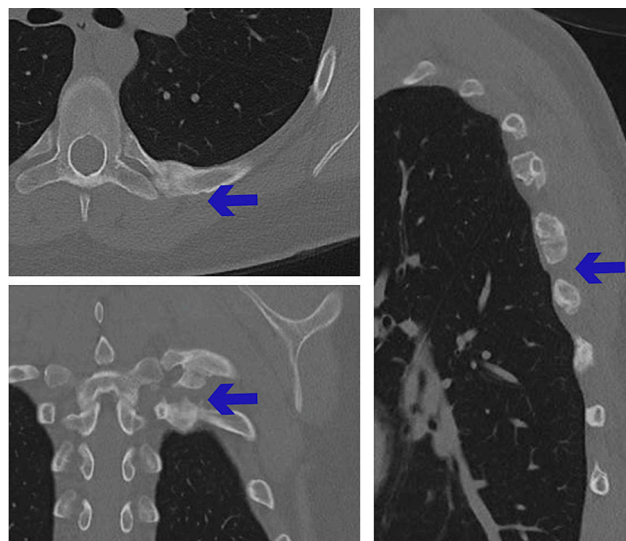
Seven months post-operative chest CT-scan demonstrating remodeled ribs 4 to 8 and partially resected heterotopic ossifications. Arrows represent the rib after resecting the protrusion of the malunion in axial view (top left) and partially resected heterotopic ossifications between the ribs in axial and sagittal view (bottom left and right).
